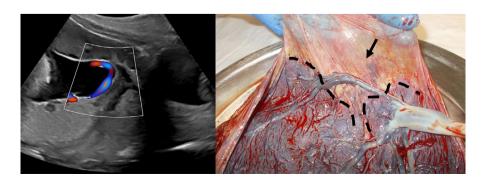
Case 3: Visualization of fetal vessels connecting two lobes of the placenta using color-coded Doppler ultrasound. (transabdominal)—bilobate placenta and the connecting vessel causing vasa previa (arrow)
